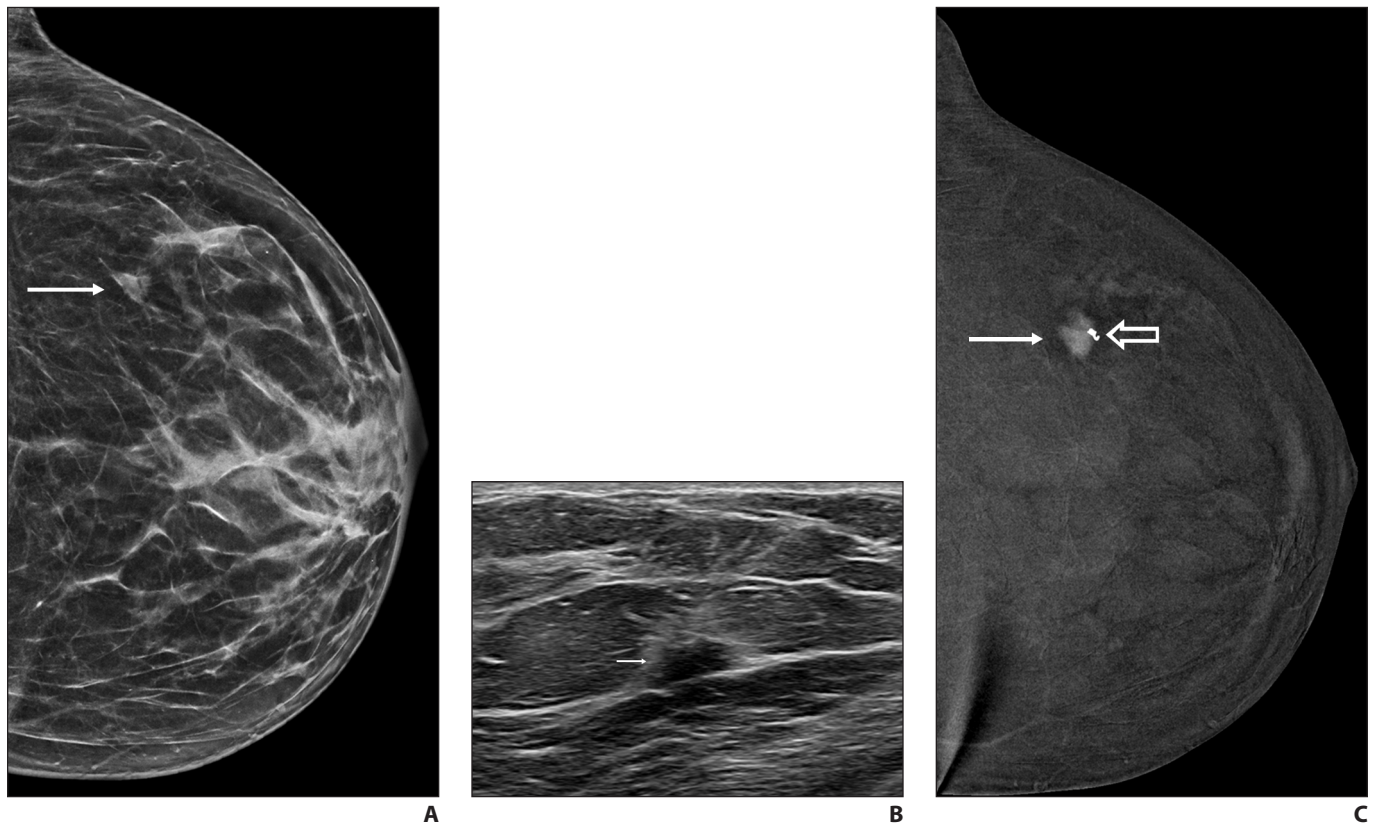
52-year-old woman with family history of breast cancer who underwent screening mammography. Asymptomatic breast cancer was initially detected on mammography and was also seen on subsequent ultrasound and contrast-enhanced mammography. A, Left craniocaudal mammogram shows mass (arrow) in outer breast. B, Left breast ultrasound shows irregular, indistinct, hypoechoic mass associated with echogenic rind (arrow) corresponding to mammographic mass. Subsequent biopsy revealed invasive ductal carcinoma. C, Contrast-enhanced mammography performed after biopsy shows that mass (solid arrow) is homogeneously enhancing on recombined craniocaudal image. Biopsy clip (open arrow) is seen at anterior aspect of mass.
